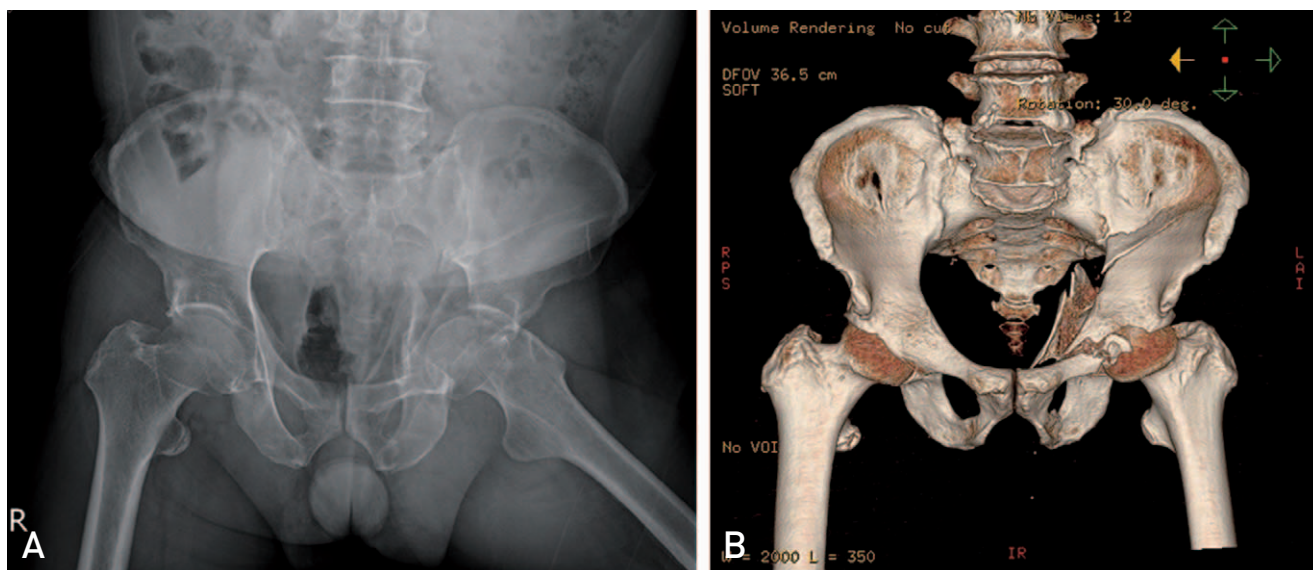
Preoperative images. (A) X-ray image. (B) Computed tomography scan.
